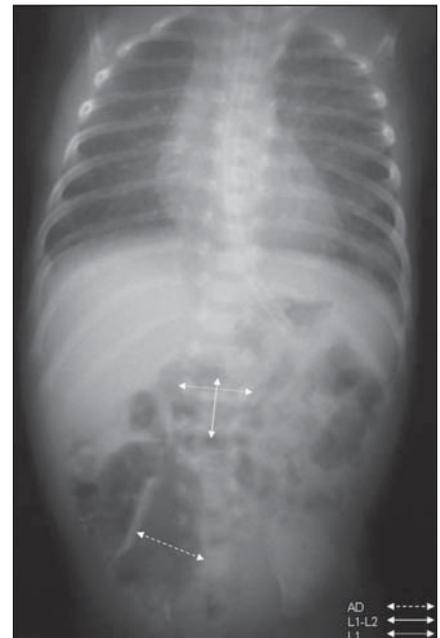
Abdominal radiograph of a neonate with necrotizing enterocolitis demonstrating the measurements utilized in the present study. AD, diameter of the most distended loop; L1, distance between the lateral edges of the first lumbar vertebra (L1) pedicles; L1-L2 - distance between the upper edge of the first lumbar vertebra and the lower edge of the second one, including the disc space.
